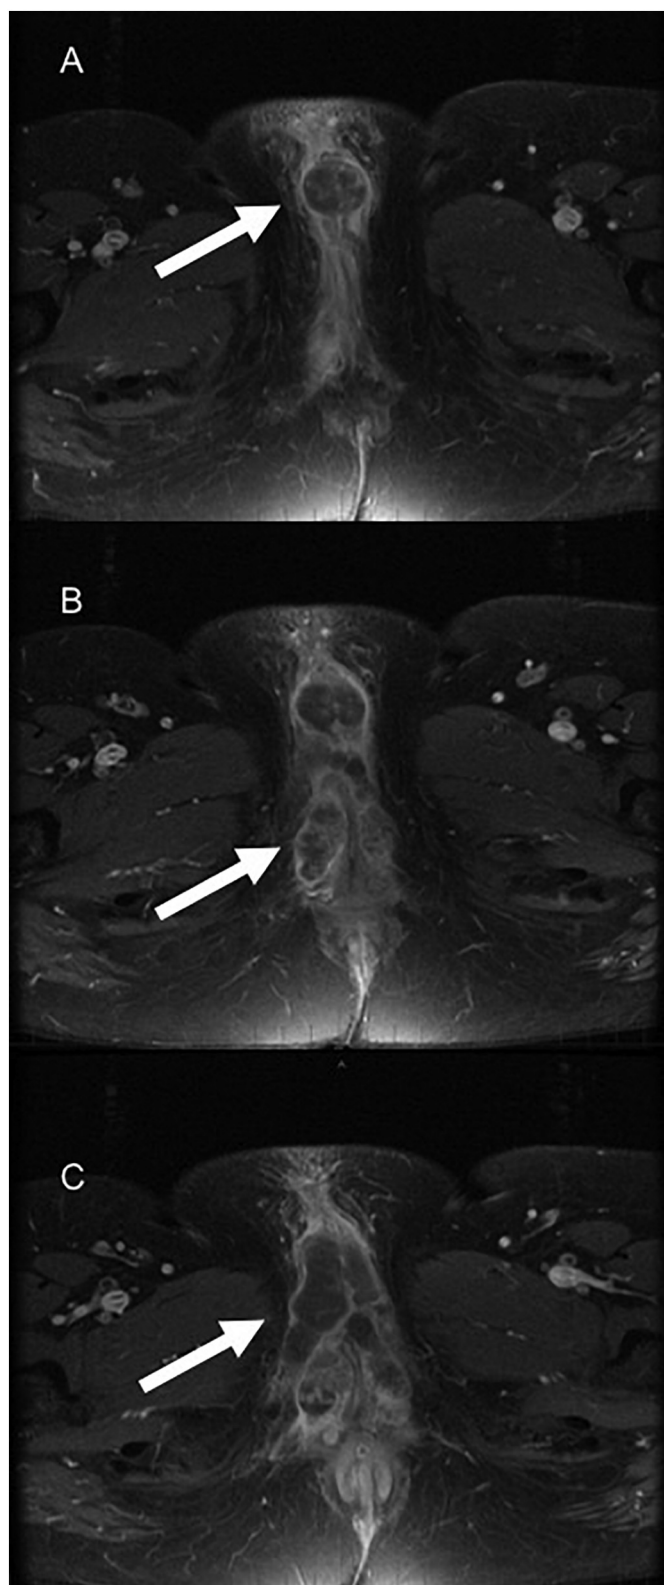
MRI of the pelvis, T2 axial images, arrows highlighting enlarged clitoris (A), and engorged corpus cavernosum bodies (B and C).
